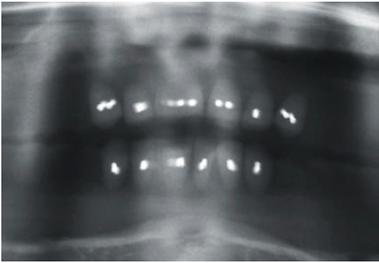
Case 1. Radiograph of female patient who desired to improve the function and stability of her maxillary and mandibular complete dentures.
